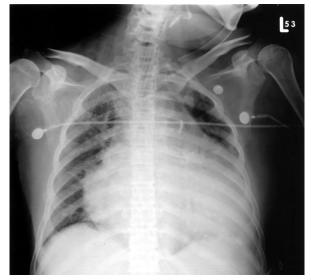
Chest radiograph taken in emergency room revealing cardiomegaly, bilateral pleural effusion and low lung volumes with intubation.
